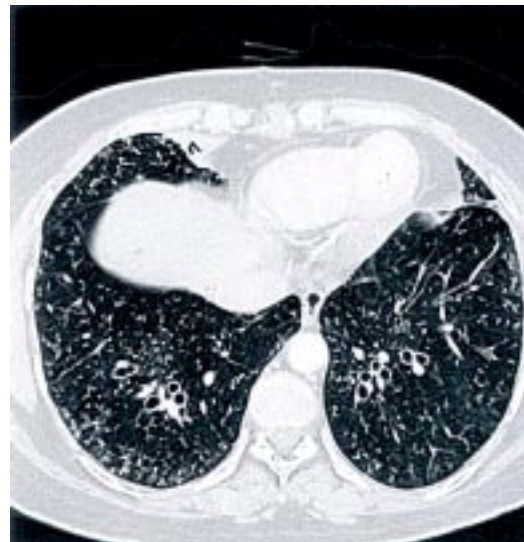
High resolution computed tomography of the thorax showing centrilobular and branching nodules and tubular bronchiectasis predominantly in the lower lobes.
